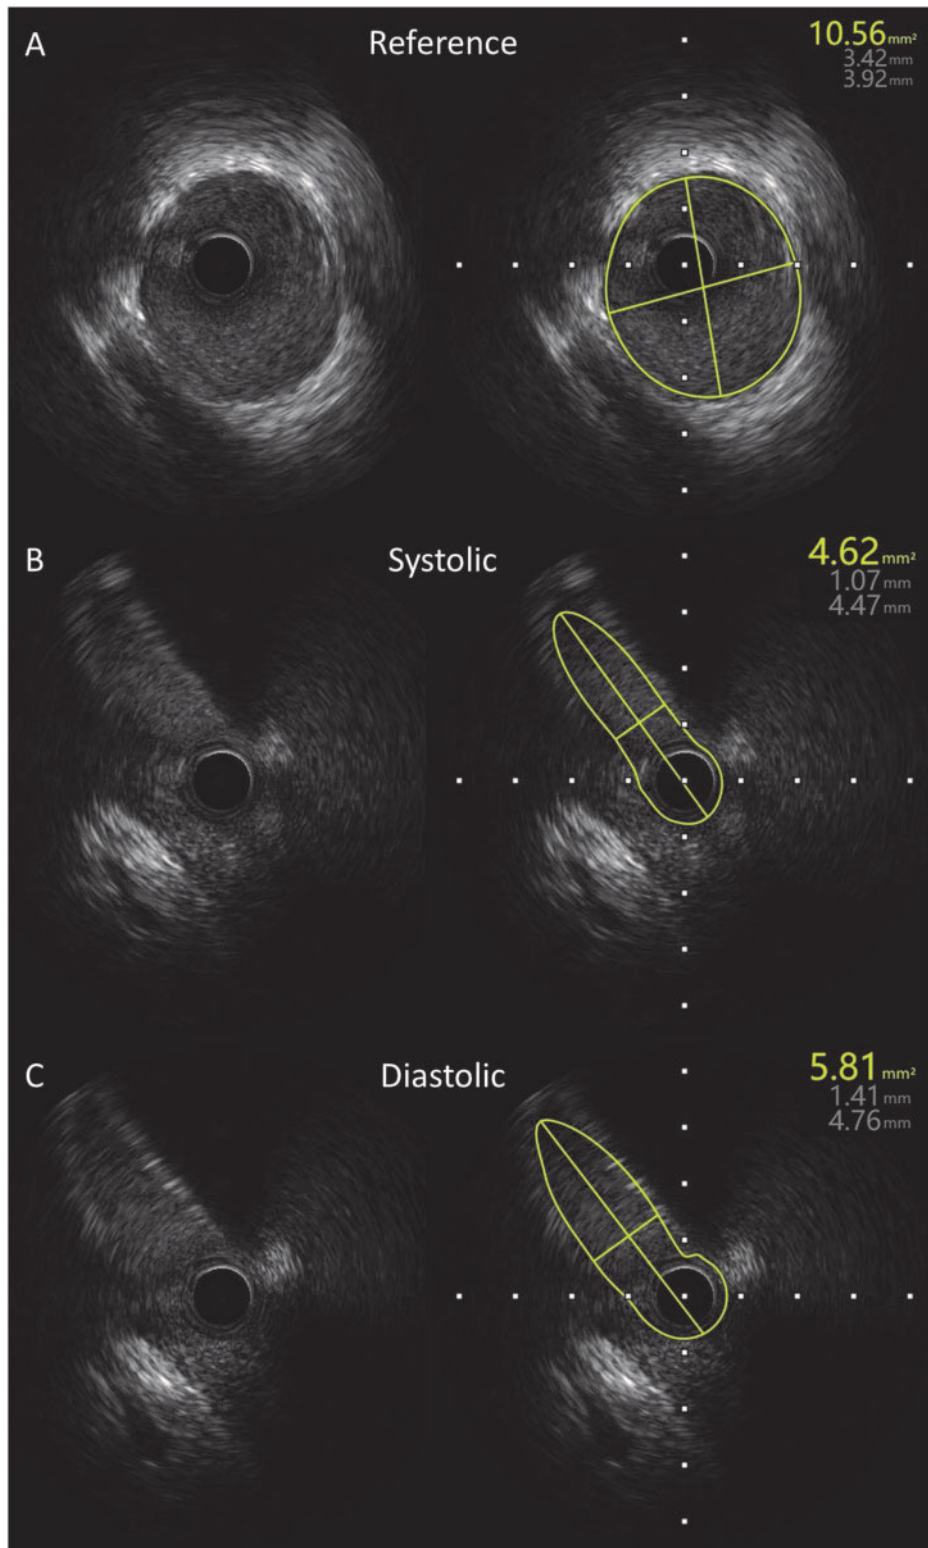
Intravascular ultrasound imaging acquisition from the proximal to ostial segment of the right coronary artery. The reference and minimal lumen diameter (D) and cross-sectional area were determined using Boston Scientific Image Viewer software. (A) Normal vessel without plaque burden at the distal reference ($D = 3.42/3.92$ mm, cross-sectional area = 10.56 mm²). (B) Slit-like orifice anatomic features close to the ostium at systolic phase ($D = 1.07/4.47$ mm, cross-sectional area = 4.62 mm², stenosis = 56%) and (C) at diastolic phase ($D = 1.41/4.76$ mm, cross-sectional area = 5.81 mm², stenosis = 45%). Interarterial segment length is 17.18 mm. Percent lumen area stenosis of anomalous coronary region determined by formula $(RA - SA)/RA \times 100\%$, where RA is the reference area and SA is the stenosis area.
